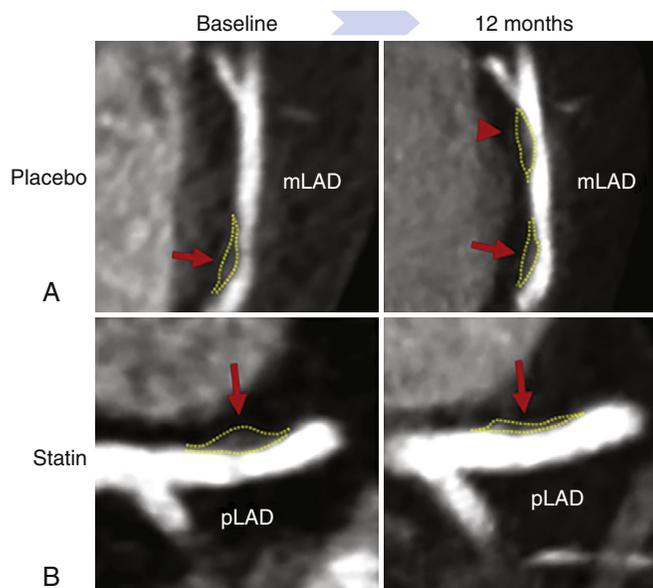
Example of coronary plaque changes on serial coronary computed tomography angiography. New mLAD plaque (*arrowhead*) developed in a participant on placebo. A, Second, more proximal mLAD plaque was unchanged (*arrow*). B, Proximal LAD plaque that regressed on follow-up after treatment with statin (*arrow*). *m LAD*, Mid left anterior descending; *pLAD*, proximal left anterior descending. (From Foldyna B, et al. Individual coronary plaque changes on serial CT angiography: within-patient heterogeneity, natural history, and statin effects in HIV. *J Cardiovasc Comput Tomogr* 2020;14:144-148.)
